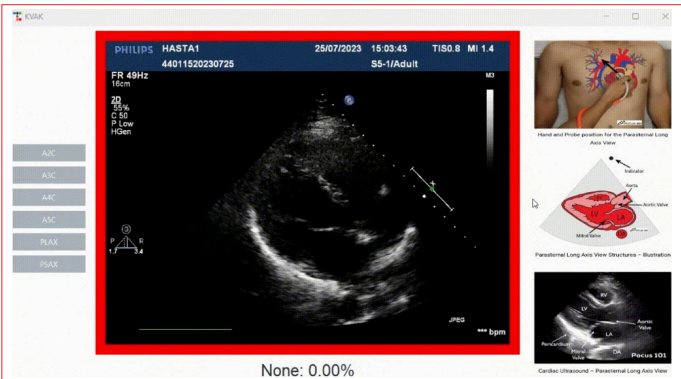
PLAX measurement to improve visualization and user-friendliness, we developed a dedicated application for our model. In this application, the user can select the desired echocardiographic view using the buttons on the left panel. On the right side, we included reference images to assist students while reviewing the selected view. The central area displays the real-time echocardiographic image. A guiding frame appears around the image: green if the correct view is approached, and red if the current view is far from the target, helping guide the user toward the correct position. At the bottom of the interface, the model's prediction and its confidence percentage are displayed. The video format of the file could not be loaded. A measurement video is available. It can be sent upon request.
